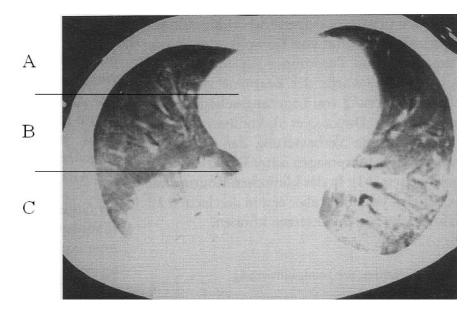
Computed tomogram of the chest in a patient with ARDS, showing the typical heterogeneous distribution of opacification within the lungs. The increased density of lung tissue in dorsal regions (A) is caused by consolidation and atelectasis. The aerated ventral regions ('baby lung' [B] have the highest compliance and tend to become overdistended (volutrauma). The interface between the two areas (C) is prone to cyclic recruitment–derecruitment (atelectrauma)
